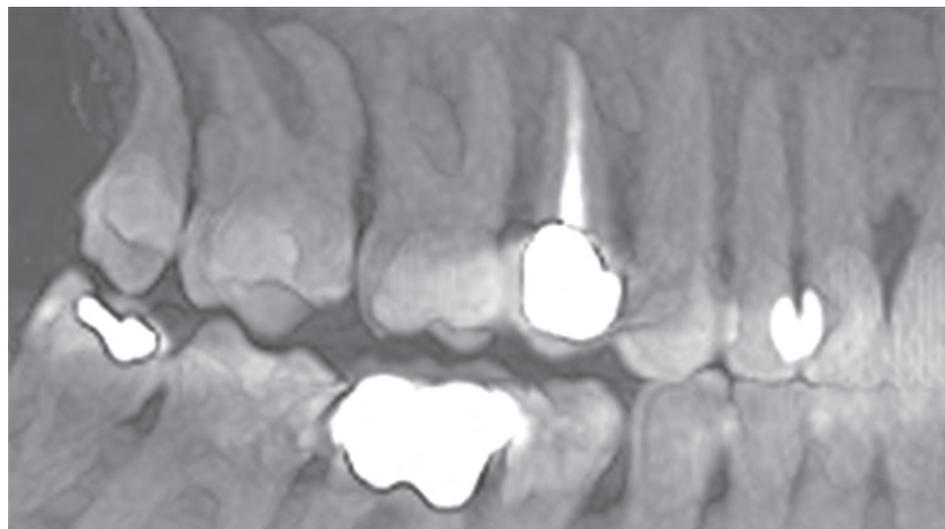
The CBCT panoramic view of the upper right quadrant
